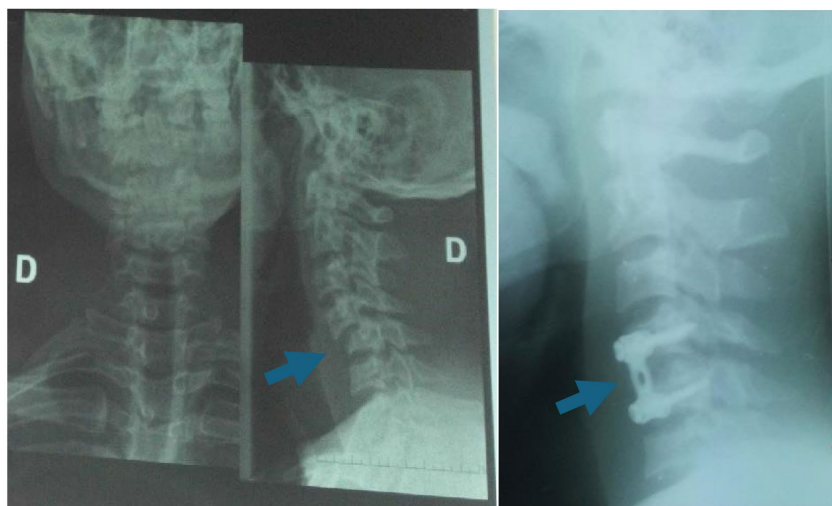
C4-C5 dislocation (standard frontal and lateral X-ray) and post-operative check-up with C4-C5 osteosynthesis by anterior cervical plate.
